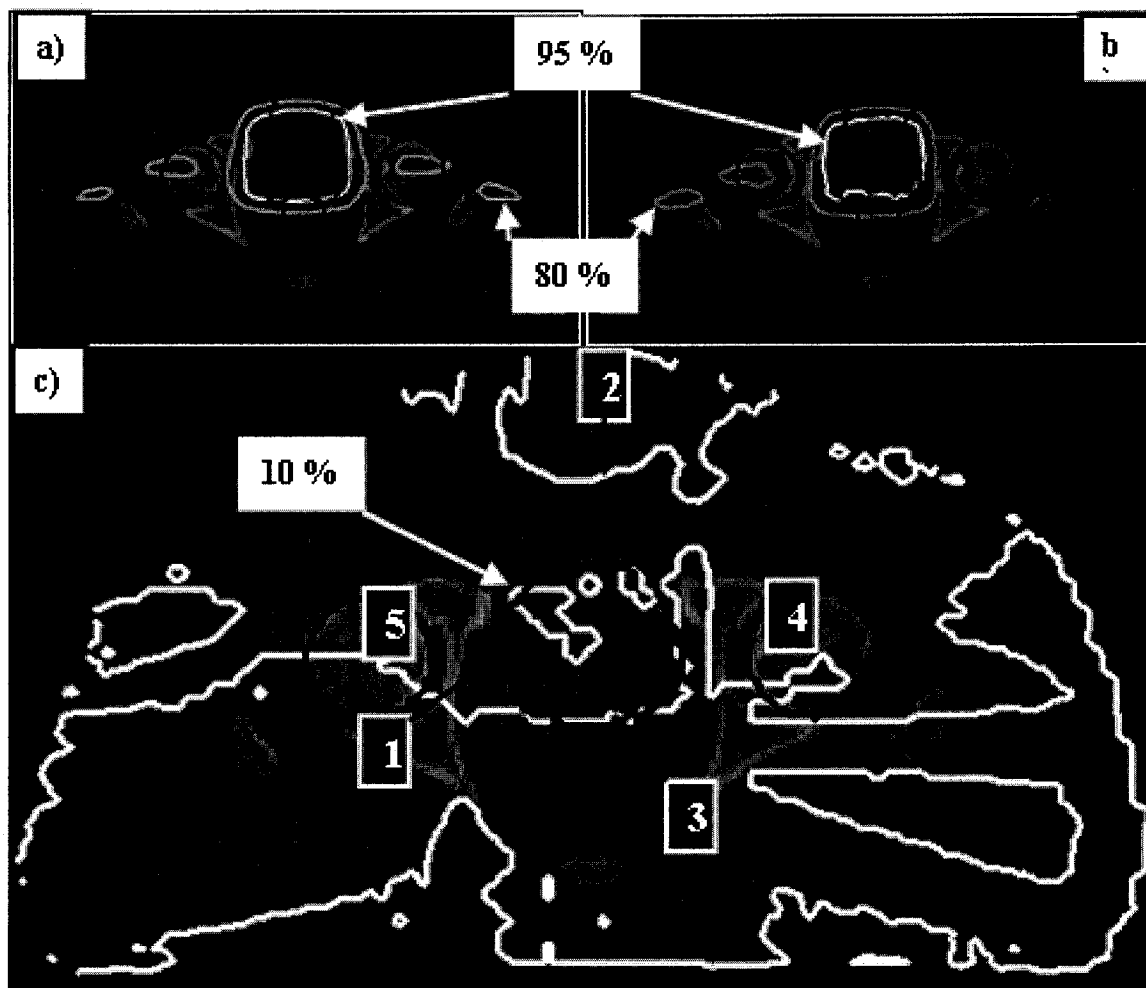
Axial CT slice showing the dose distributions for patient 4 (worst case) from (a) CADPLAN without corrections and (b) XVMC. (c) The dose ratio with organ contours; (1) prostate, (2) bladder, (3) rectum, (4) left femur and (5) right femur.
